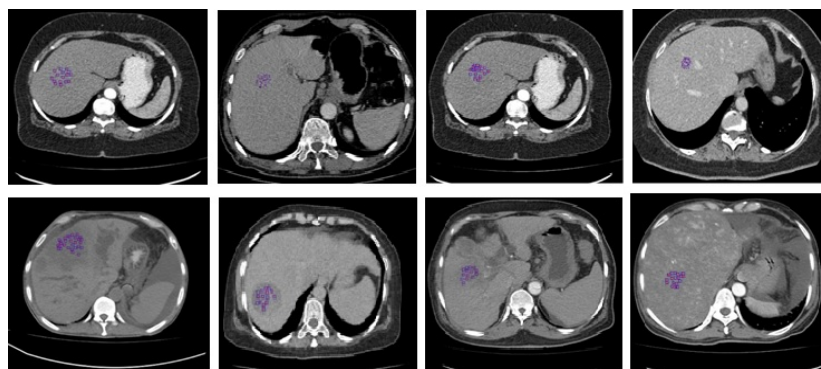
Construction of ROIs for the conventional machine learning methodology. Column 1: CT image of a normal class 1 liver versus an infected liver; column 2: CT image of a normal class 2 liver versus a metastatic liver, column 3: CT image of a normal class 3 liver versus a metastatic liver; column 4: CT image of a normal class 4 liver versus an abnormal vascular area in the liver.
